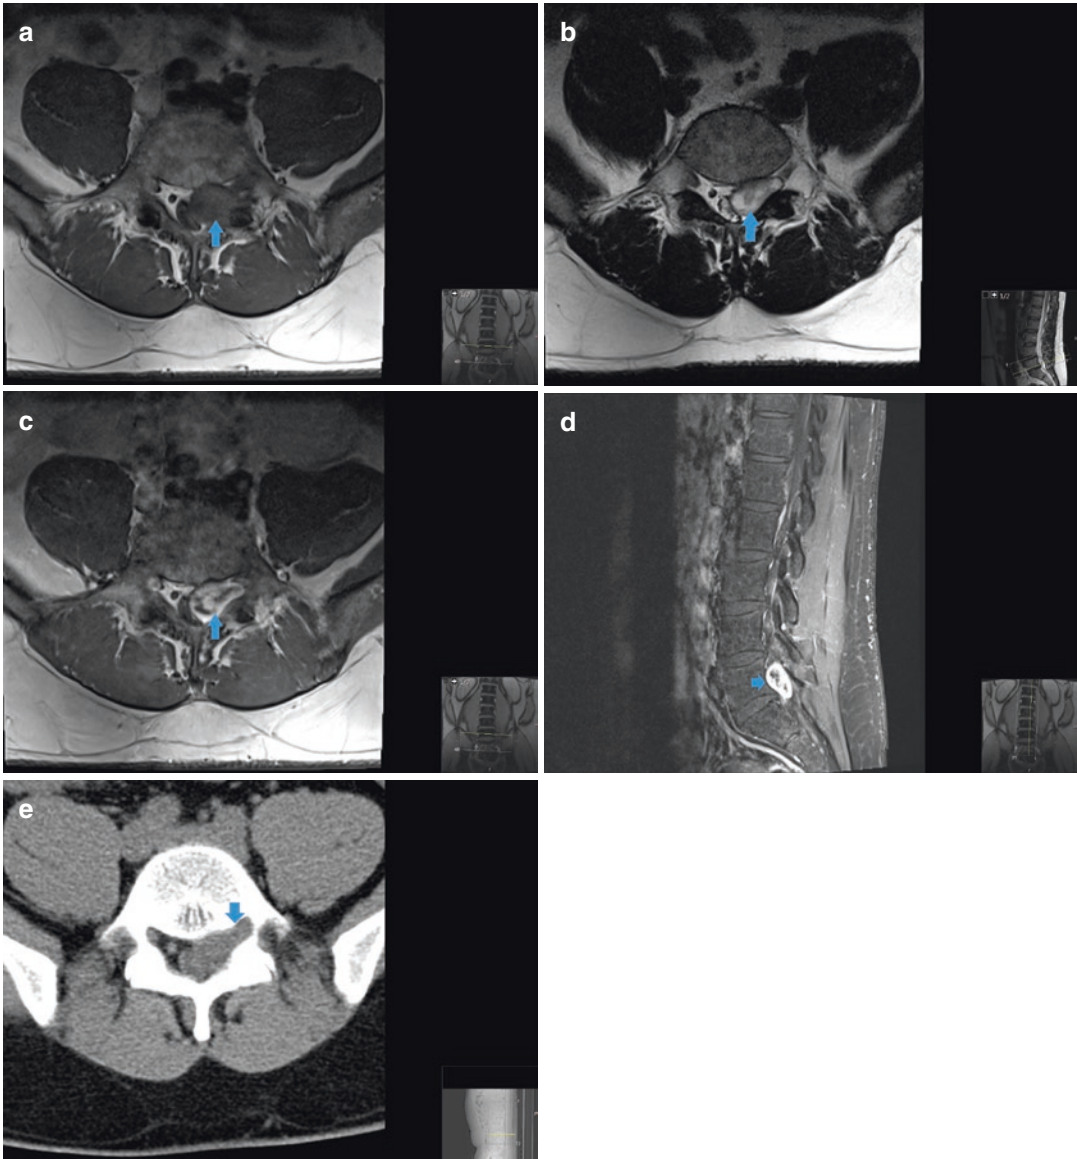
Schwannoma. Figure 9.9a is an axial T1-weighted MR image showing an intradural extramedullary mass centered in the left lower lumbar thecal sac, extending through the left L4–L5 neural foramen (arrow). The lesion has a mild dumb-bell-shaped appearance, is mildly hyperintense on the T2-weighted MR
